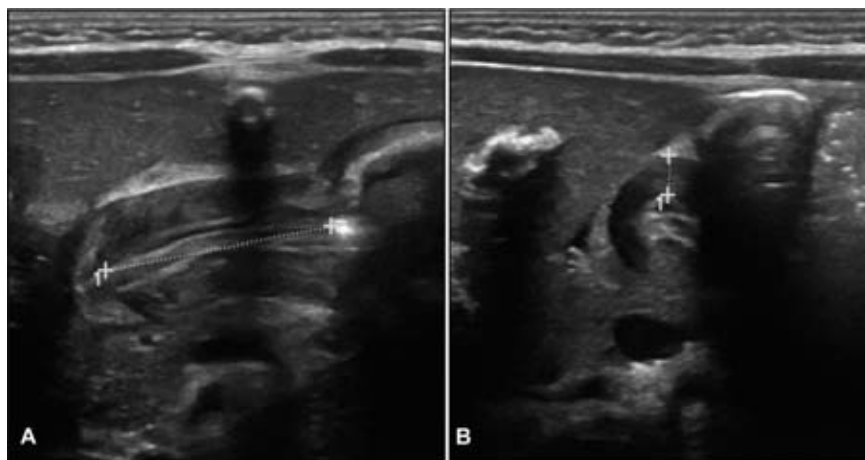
A) Ultrasound images in this patient show a pyloric muscle length of 20 mm, and B) thickness of 5 mm consistent with the diagnosis of hypertrophic pyloric stenosis. During the dynamic study, no passage of fluid through the pyloric channel was seen.
